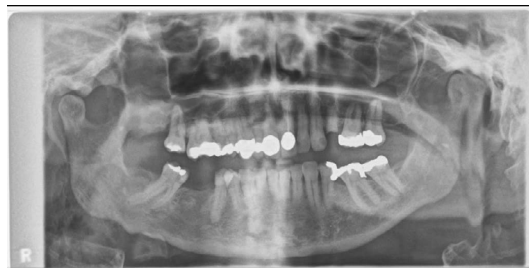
Panoramic radiograph showing carious lower right 5 and lower right 7, with periapical pathology associated with both teeth. The radiopacities in the right mandible reveal a chronic sclerosing osteitis, indicative of a long standing infection. Gas is also seen in the soft tissues around the right ramus.
